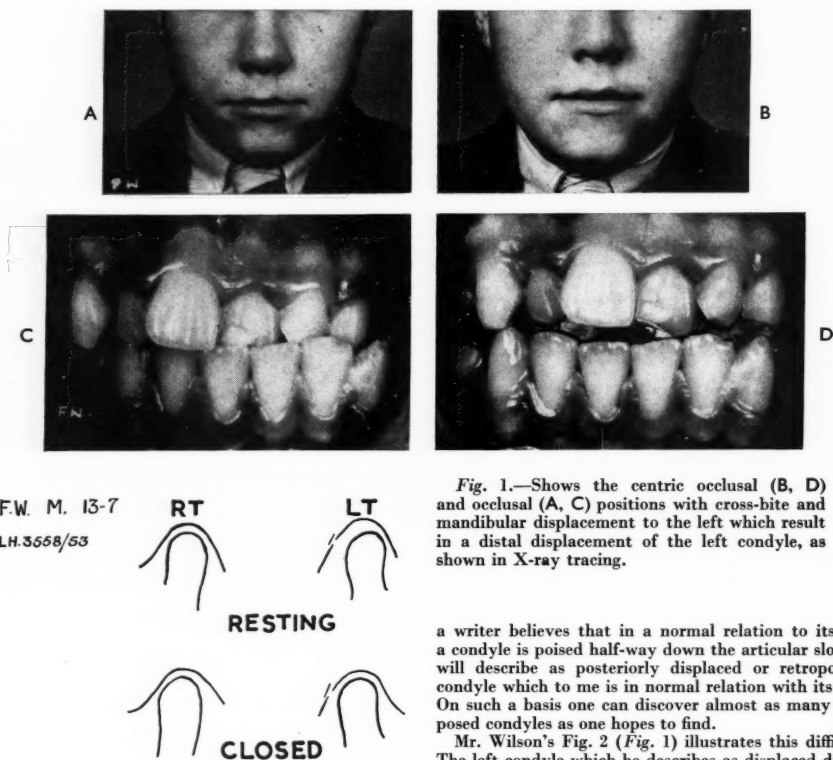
Shows the centric occlusal (B, D) and occlusal (A, C) positions with cross-bite and mandibular displacement to the left which result in a distal displacement of the left condyle, as shown in X-ray tracing.
